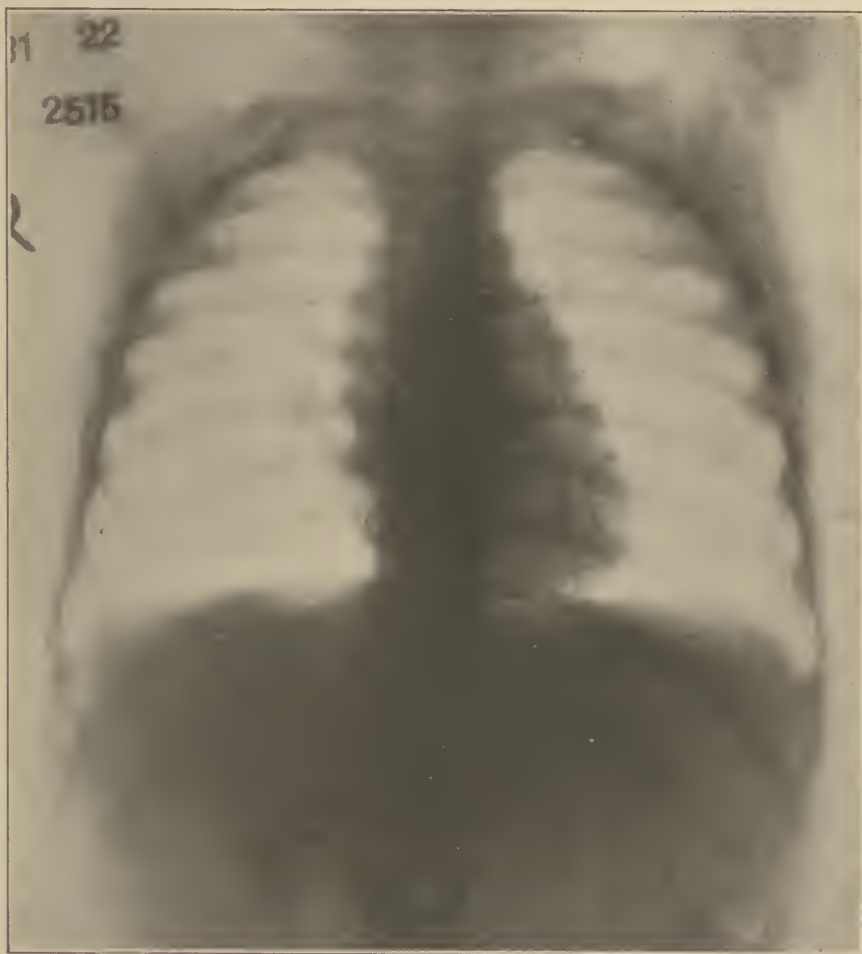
Same patient after one x-ray treatment. Thymus gland reduced to normal size.
